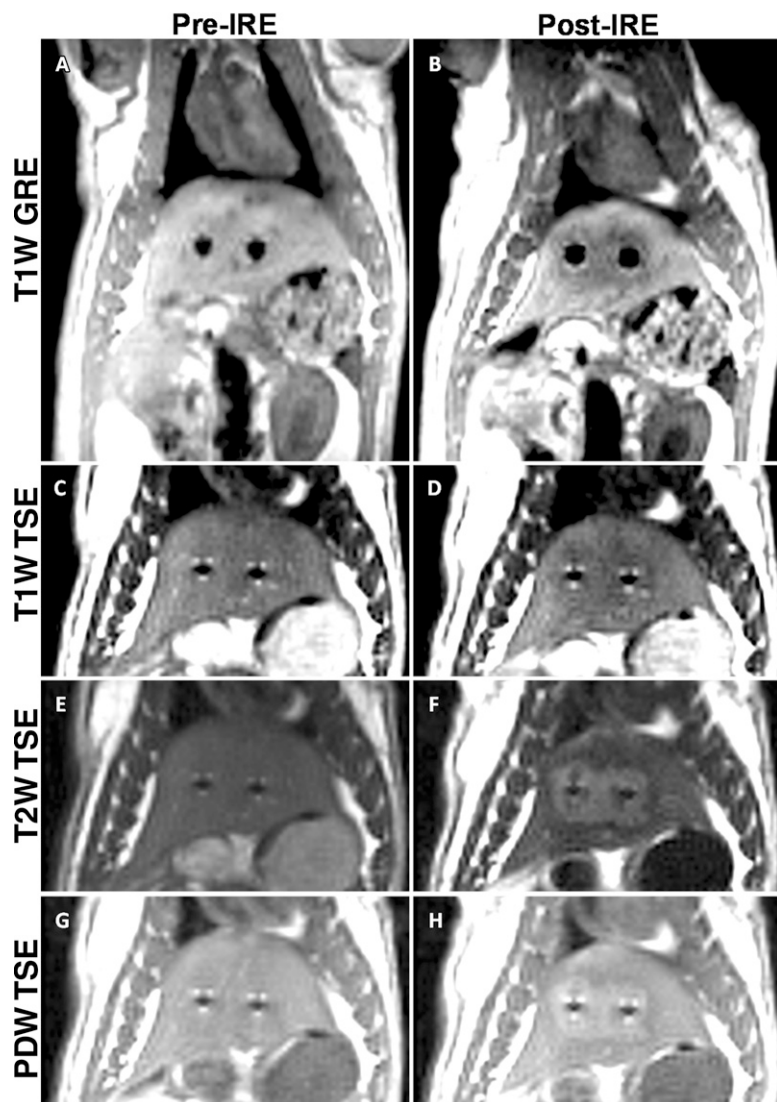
Representative MR images acquired perpendicular to the electrodes before (*Pre-IRE*) and immediately after (*Post-IRE*) IRE with 2500-V pulses. *A, B*, T1-weighted (*T1W*) GRE images; *C, D*, T1-weighted TSE images; *E, F*, T2-weighted (*T2W*) TSE images; *G, H*, proton-density-weighted (*PDW*) TSE images. Bipolar electrode positions are depicted as signal voids. Ablation zones are hypointense on T1-weighted images and hyperintense on both T2- and proton-density-weighted images.
